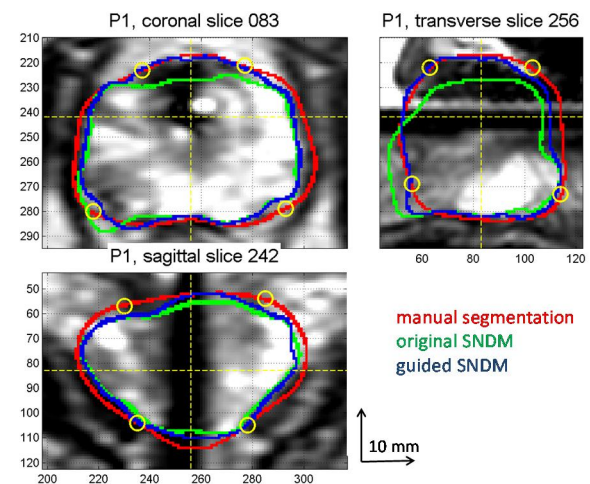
T2-weighted image for patient 1 with prostate segmentations in comparison. Green contour shows original SNDM fitting for prostate boundary, based on T2-weighted planning image only, and blue contour shows suggested guided SNDM fitting method using T1-weighted preparation image also.
